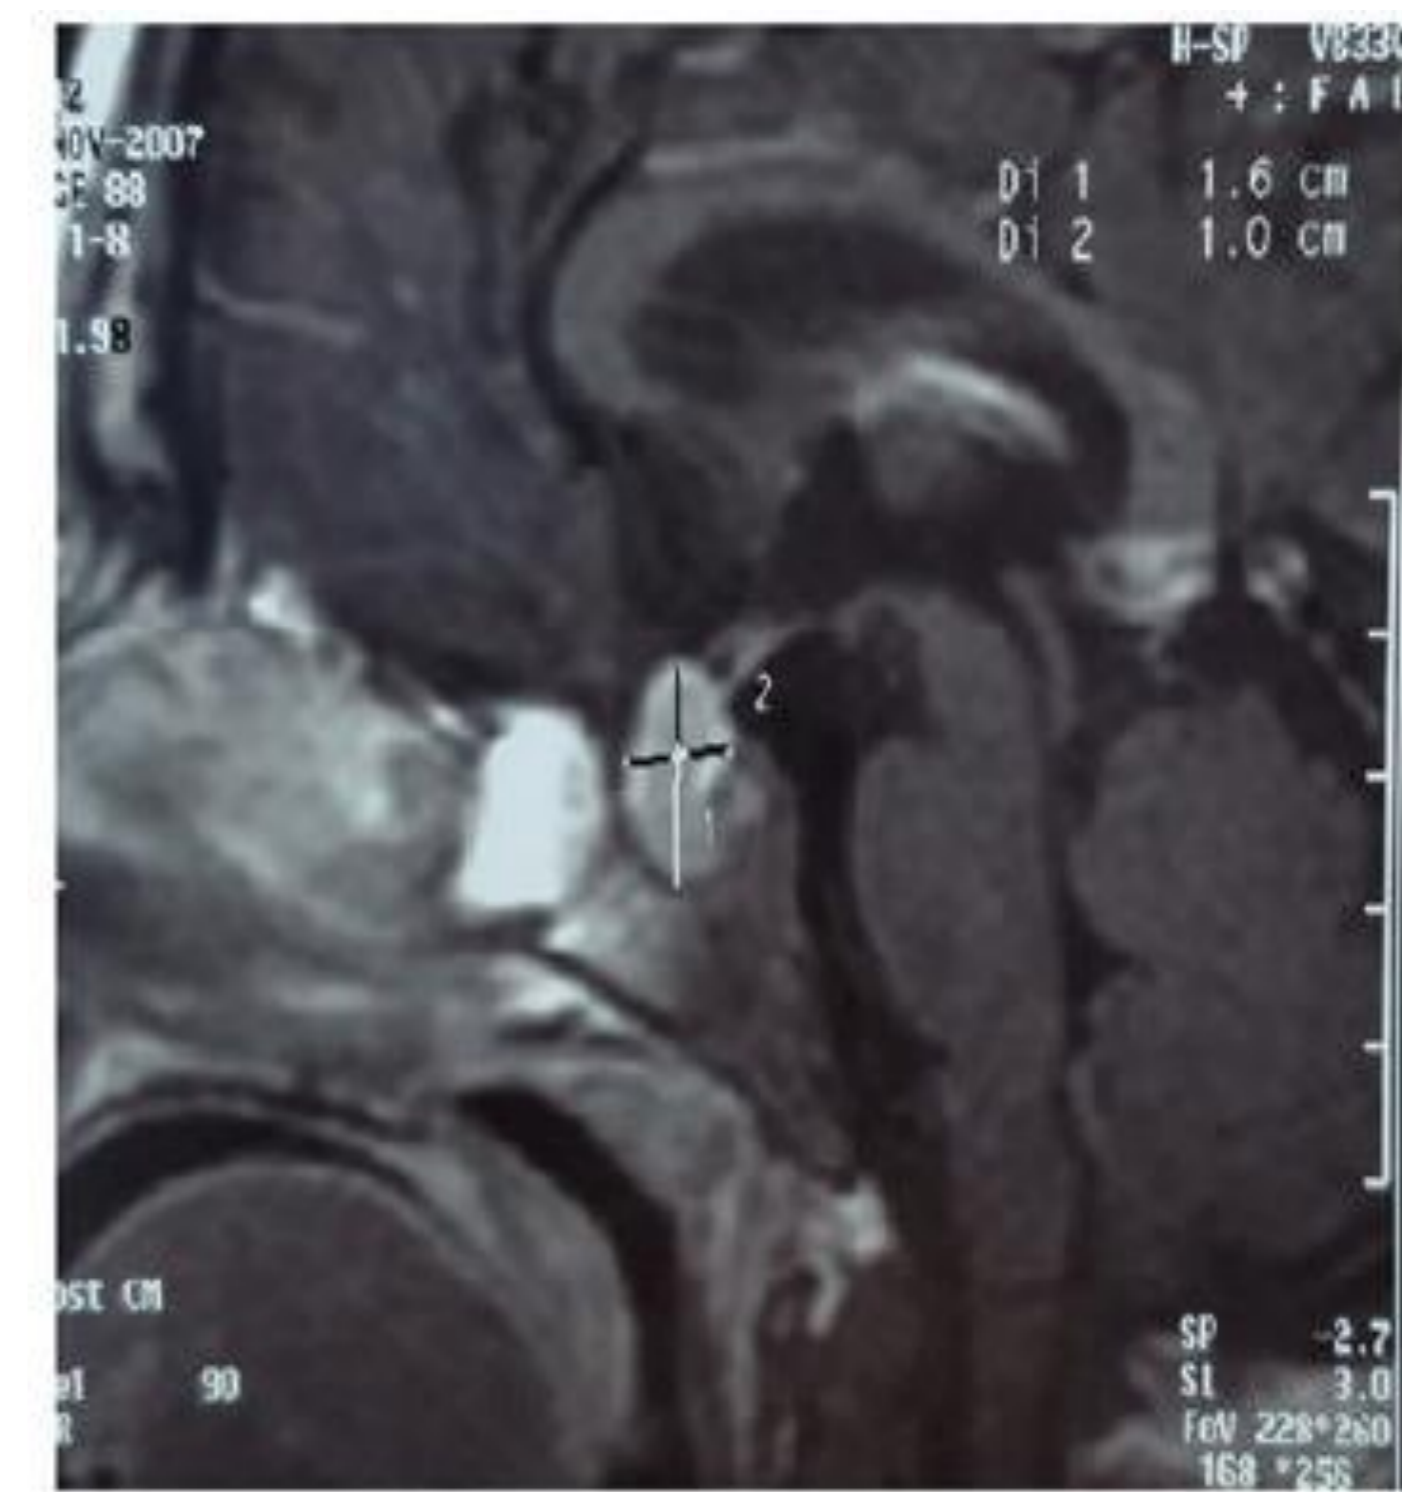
Initial MRI of the pituitary gland. Post enhanced T1 weighted sagittal MRI shows marked enlargement of the pituitary gland that extends slightly into the suprasellar region, with homogeneous enhancement
